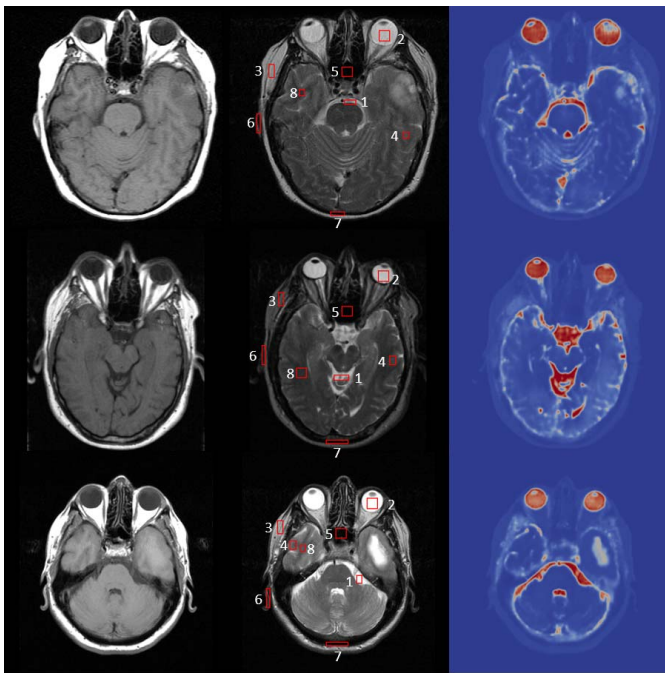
From left to right: T1-, T2-weighted MRI, and CondNet non-uniform conductivity maps. From top to bottom: subjects TCGA-02-0006, TCGA-14-1794, and TCGA-19-0963. The labeled ROIs represent CSF, V. humor, fat, GM, mucous tissue, skin, bone cort., and WM, in order.
